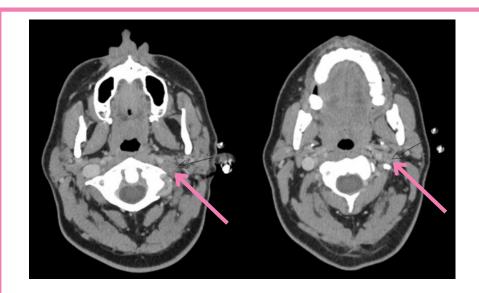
CT neck showing left transverse sinus thrombus extending to the level of the angle of mandible.
